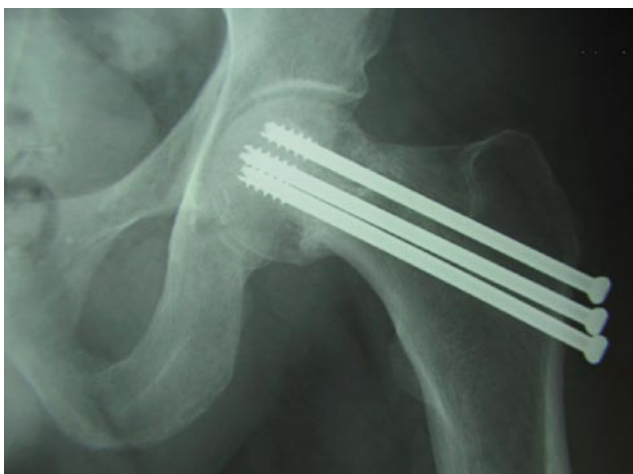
Case 1—Anteroposterior x-ray of left hip at 8 months follow-up shows healing of femoral neck fracture.
